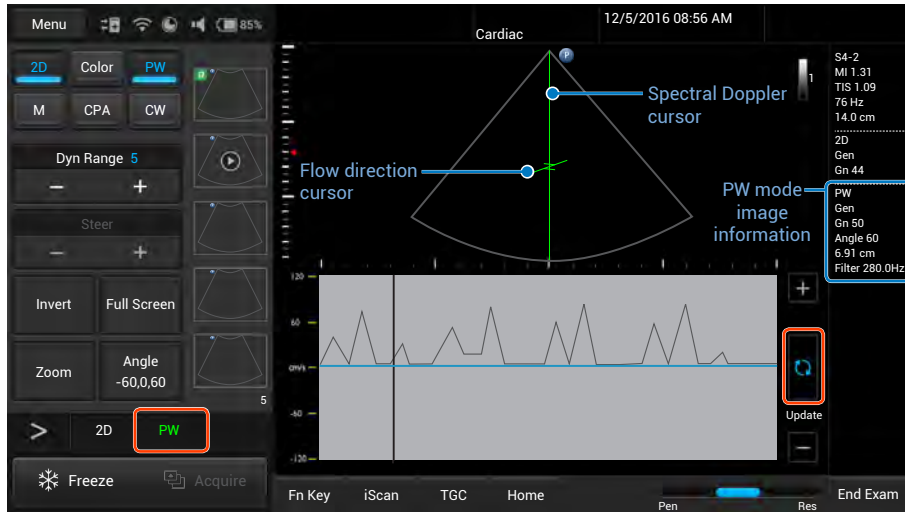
PW Doppler mode real-time scan
